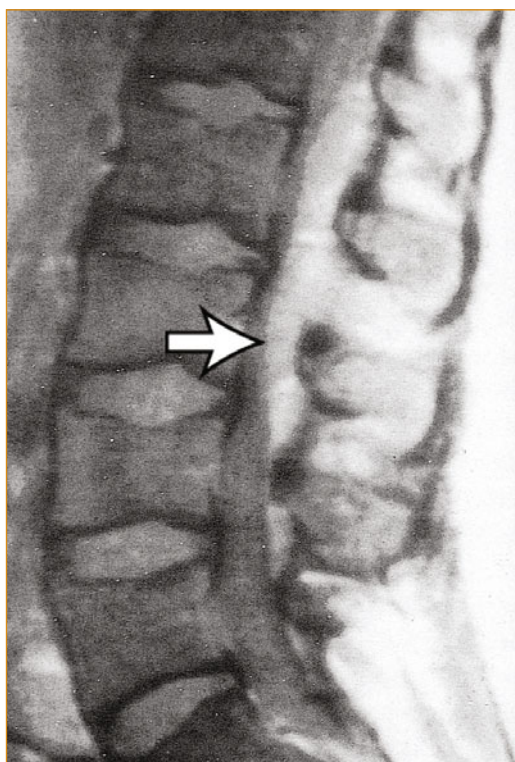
Contrast-enhanced T1-weighted MRI done as part of a diagnostic work-up for spinal epidural abscess. This scan reveals an epidural mass (*arrow*) extending from the lower part of the L1 vertebral body to the upper part of the L4 vertebral body. Patients with acute spinal epidural abscess have a high peripheral leukocytic count from 12,000 to 15,000 cells per mm^3 . If the process is chronic, the peripheral leukocyte count may be normal. Cerebrospinal fluid (CSF) examination is consistent with parameningeal infection, with an elevated cell count, elevated protein level, normal glucose level, and negative cultures. When the process is acute, usually polymorphonuclear leukocytes predominate, with up to 100 to 200 cells per mm^3 ; in chronic cases, mononuclear cells predominate, usually with fewer than 50 cells per mm^3 . CSF cultures are negative unless the organism has spread to the CSF and subsequently caused meningitis. Blood cultures are positive 60% to 70% of the time. The definitive diagnostic studies, however, are CT myelograms and MRI scans, with MRI the study of choice. MRI scans directly visualize the extent of the abscess and should include T1-weighted images before and after contrast enhancement and a T2-weighted image.
